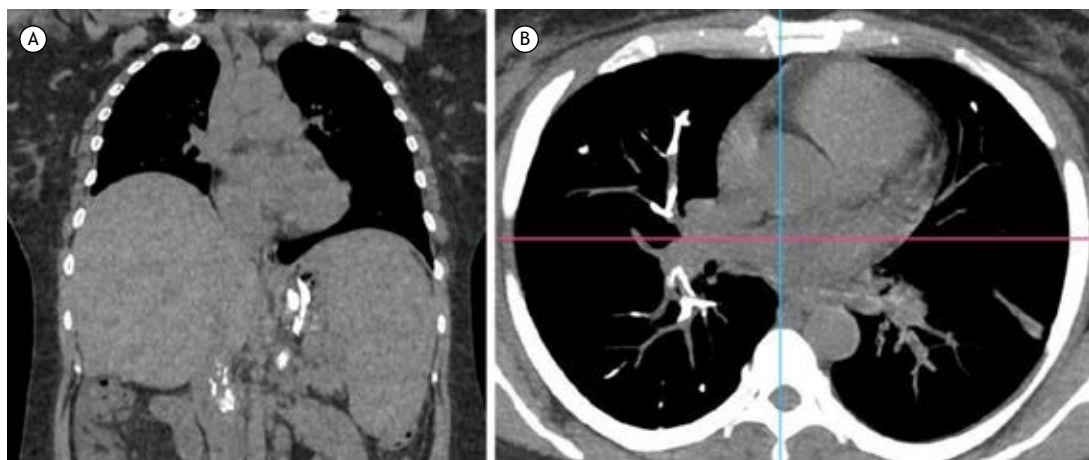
In A, a coronal section of chest CT showing hyperdense material in the topography of the gastric fundus, splenic hilum, left renal vein, and inferior vena cava, which is compatible with hemostasis material. In B, the axial section also showed hyperdense material in the segmental branch of the middle lobe and in the medial basal subsegmental branch of the right lower lobe, leading to partial filling failure, which is compatible with cyanoacrylate pulmonary embolization.
